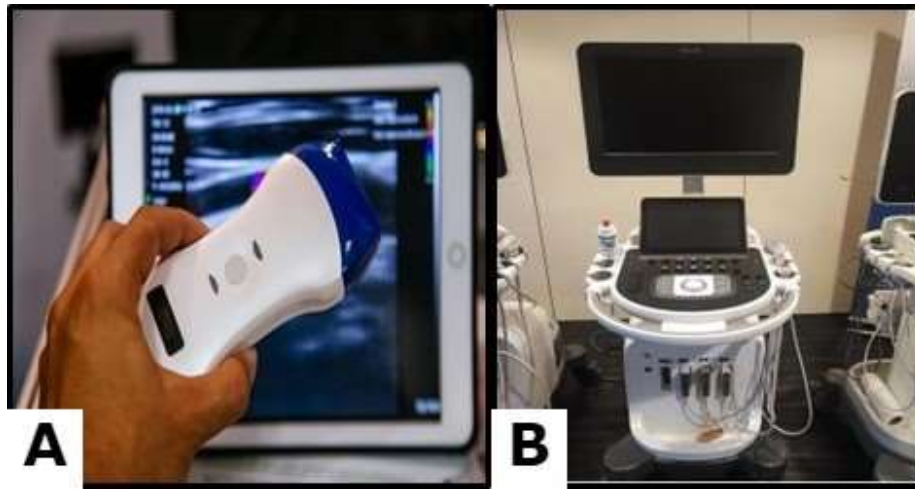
Ultrasound device A) Wireless Handheld Ultrasound; B) PHILIPS Ultrasound Device)
